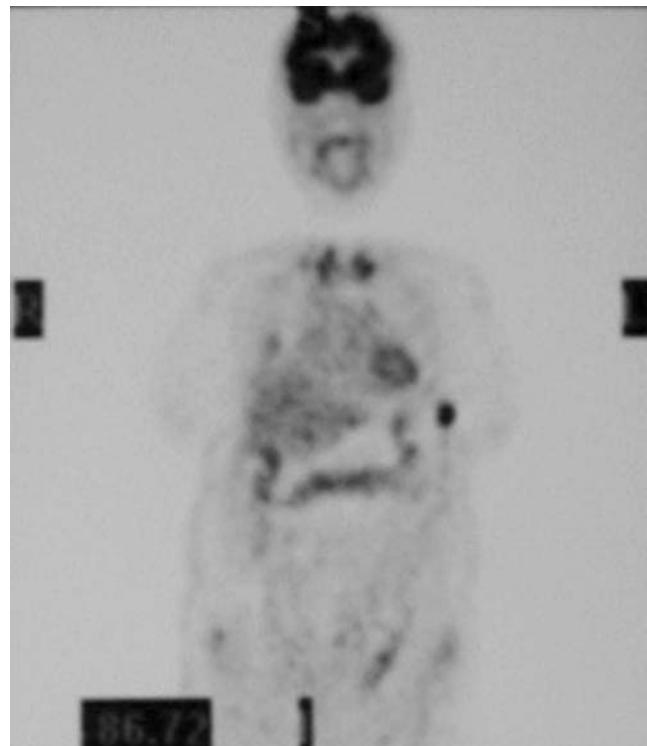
PET scan image showing a hotspot on the left side of the chest (a combination of PET/CT scans show that the deposit is in the intercostals muscle—not shown)
